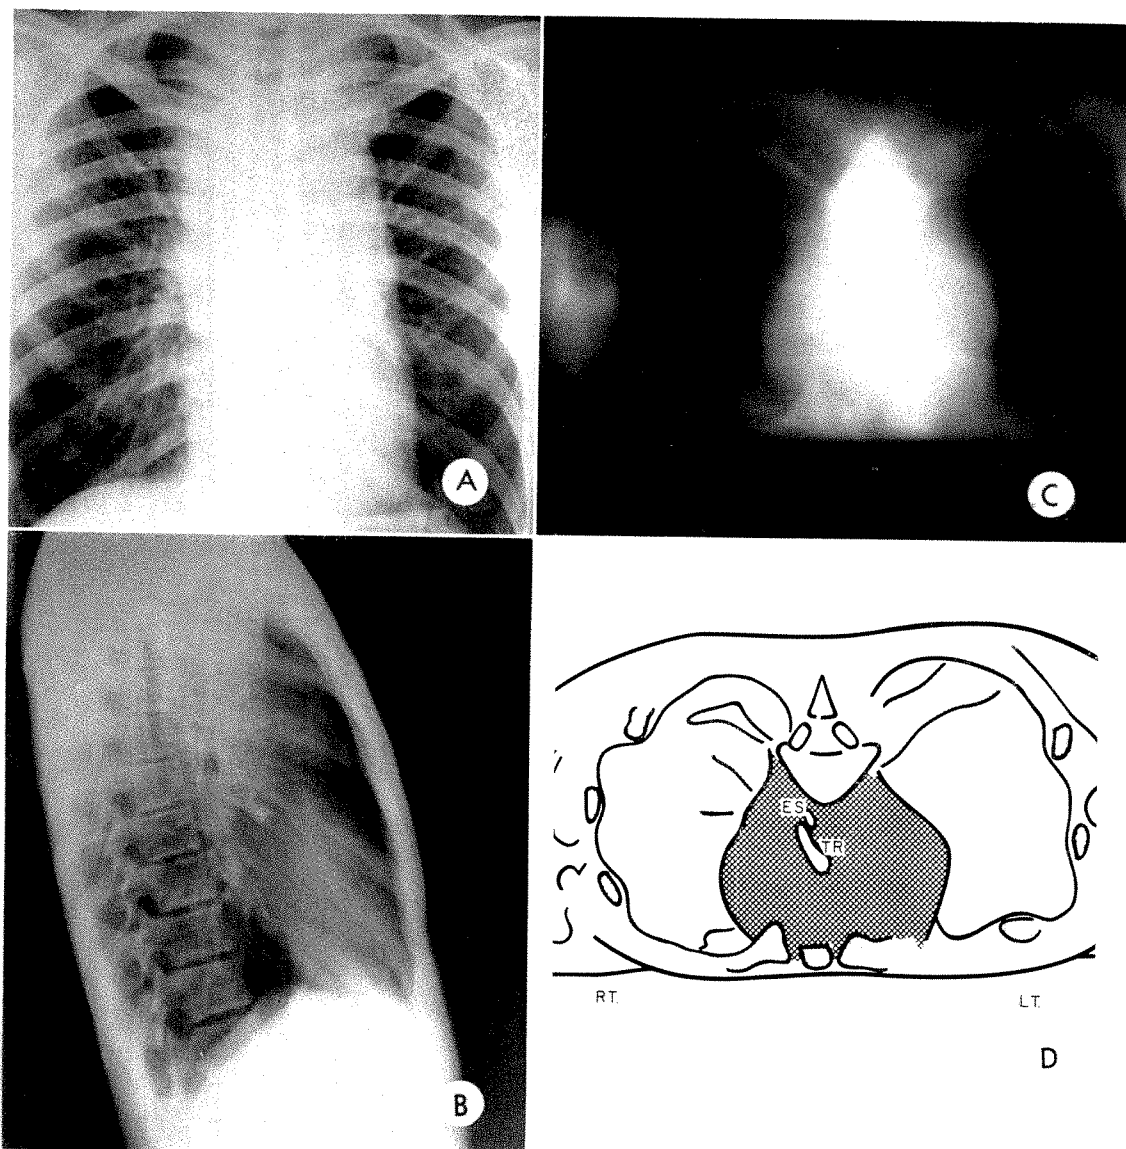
Case v. This was a twenty year old white male with the diagnosis of mediastinal Hodgkin's disease. Posteroanterior and lateral chest roentgenograms (A and B) show huge bilateral mediastinal polycyclic masses.
